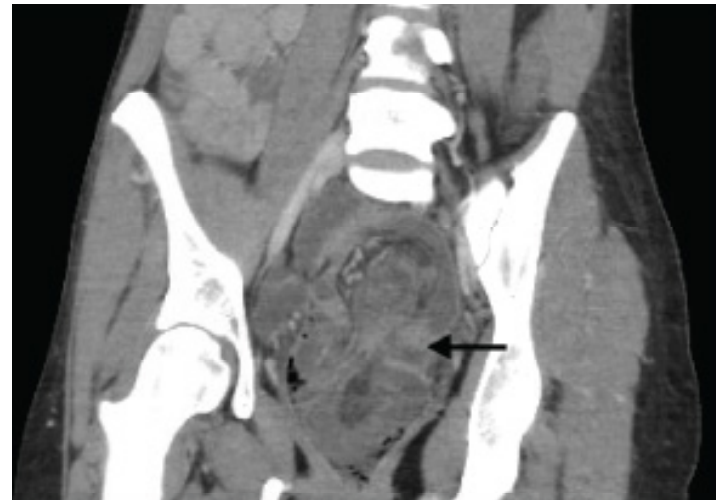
Coronal computed tomography view showing edematous sigmoid colon containing intussuscepted descending colon (black arrow).
